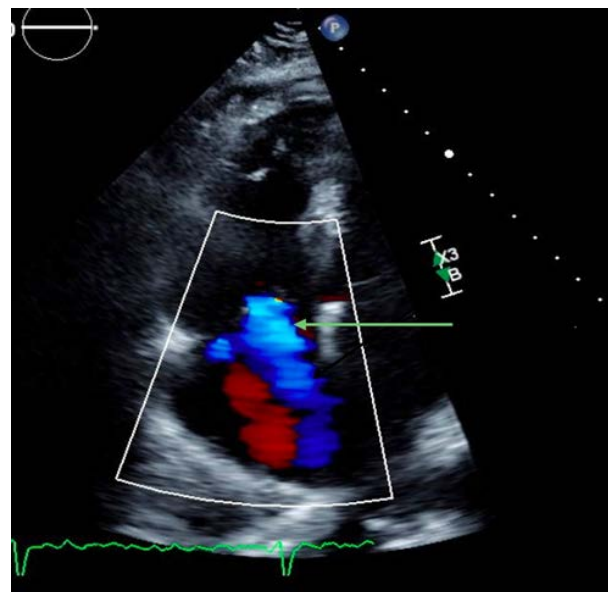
2D Echocardiogram, Color doppler demonstrating tricuspid regurgitation (green arrow), an indirect marker of severity of pulmonary hypertension.
